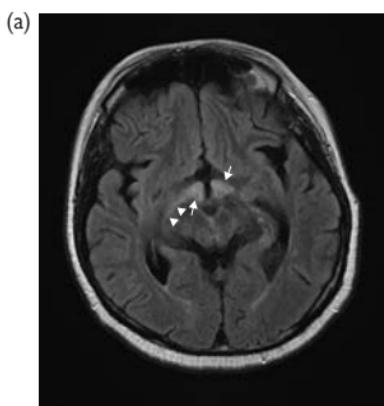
Neurosarcoidosis (a) FLAIR axial; (b) and (c) axial and coronal post contrast enhanced MRI. There is hyperintensity, expansion and peripheral enhancement of the optic chiasm and hypothalamus (*small white arrows*) with extension of abnormal signal posteriorly along the right optic tract ((a) *white arrowheads*).
